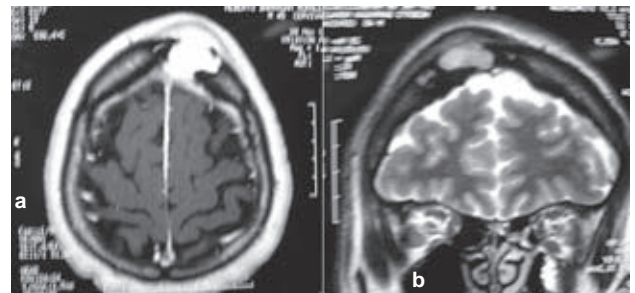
a. The brain MRI-image showed a left frontal hyperintense mass with peripheral enhancement, affecting soft tissues, bone and meninges. b. IRM coronal plane Gadolinium-enhanced imaging showing heterogeneously enhancing in meningeal and subcutaneous lesion that spares the encephalon.
